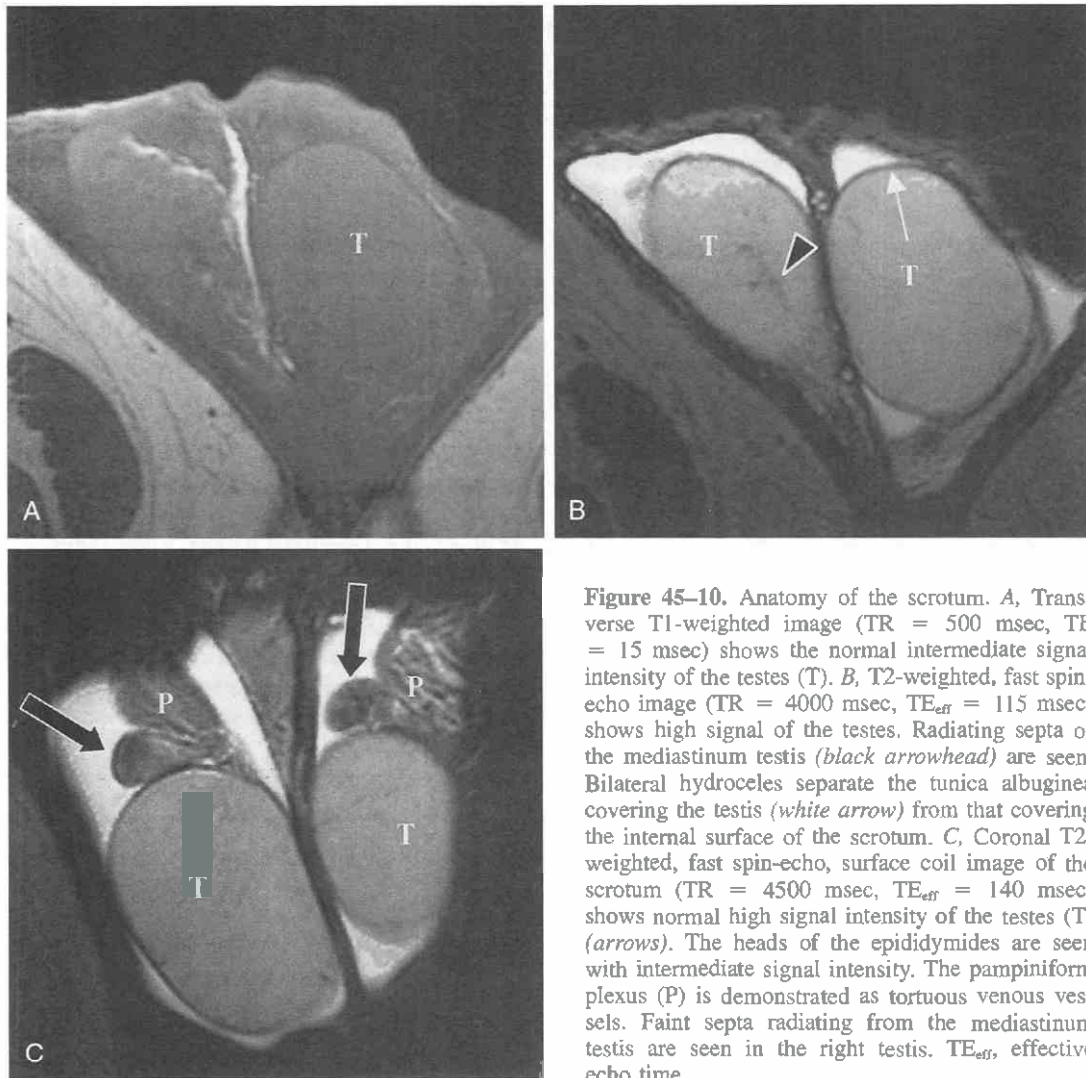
Anatomy of the scrotum. A, Transverse T1-weighted image (TR = 500 msec, TE = 15 msec) shows the normal intermediate signal intensity of the testes (T). B, T2-weighted, fast spin-echo image (TR = 4000 msec, TE_{eff} = 115 msec) shows high signal of the testes. Radiating septa of the mediastinum testis (black arrowhead) are seen. Bilateral hydroceles separate the tunica albuginea covering the testis (white arrow) from that covering the internal surface of the scrotum. C, Coronal T2-weighted, fast spin-echo, surface coil image of the scrotum (TR = 4500 msec, TE_{eff} = 140 msec) shows normal high signal intensity of the testes (T) (arrows). The heads of the epididymides are seen with intermediate signal intensity. The pampiniform plexus (P) is demonstrated as tortuous venous vessels. Faint septa radiating from the mediastinum testis are seen in the right testis. TE_{eff}, effective echo time.
